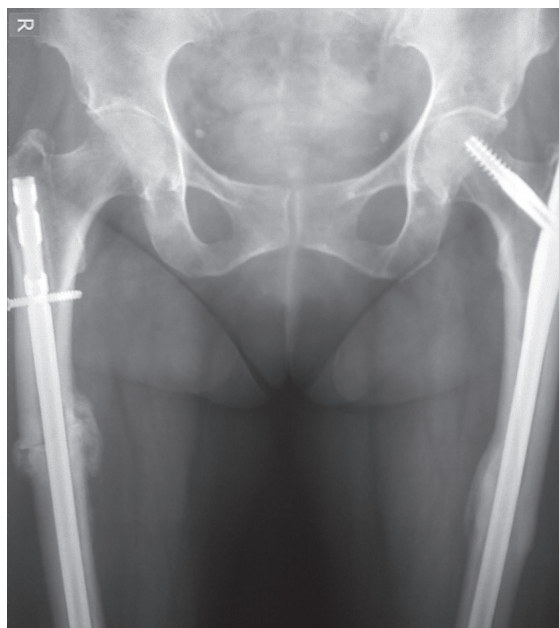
Anteroposterior radiograph of both femurs 5 months after the second operation, showing healing of the fracture with callus formation.
